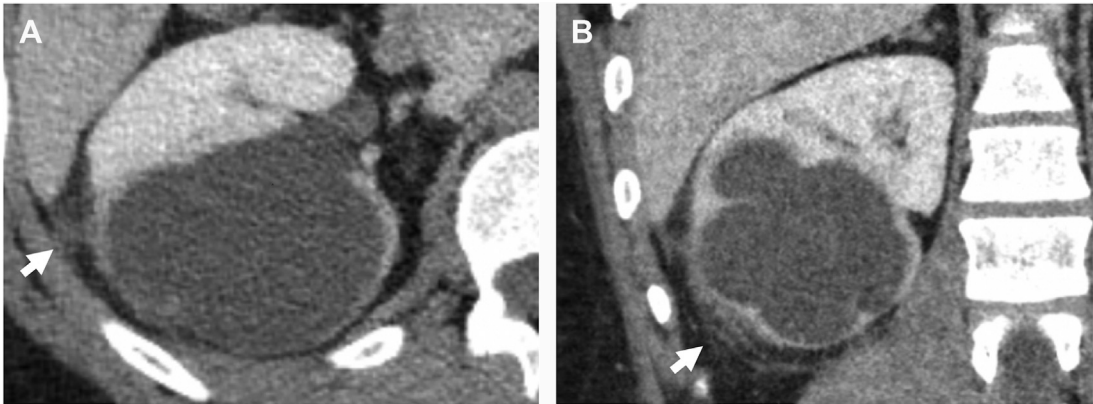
A 45-year-old woman with abdominal pain, leukocytosis, and lower urinary tract symptoms. On the portal venous CT scan, a cystic-appearing renal mass with thickened walls and multiple thin internal septations is present, along with mild edema (*arrows*) in the surrounding perirenal fat (*A, B*). This lesion was correctly identified as a renal abscess, and the Bosniak classification system was not applied. The abscess subsequently resolved on intravenous antibiotic therapy (*B*).
